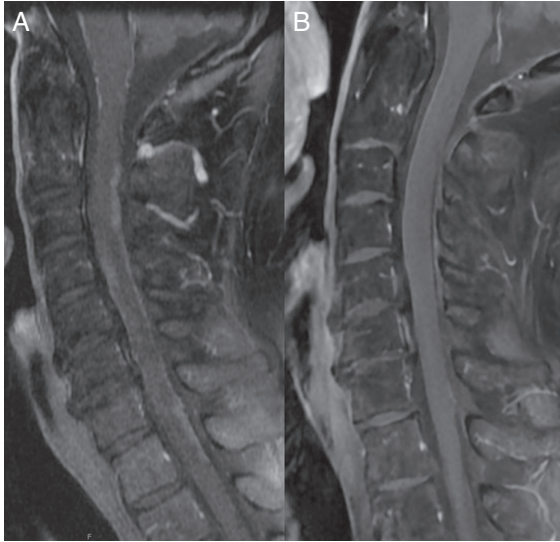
T1 post-contrast MRI cervical spine studies showing (a) recurrence with leptomeningeal carcinomatosis predominately along the dorsal cervical thecal sac and (b) post-treatment resolution of the leptomeningeal enhancement.
